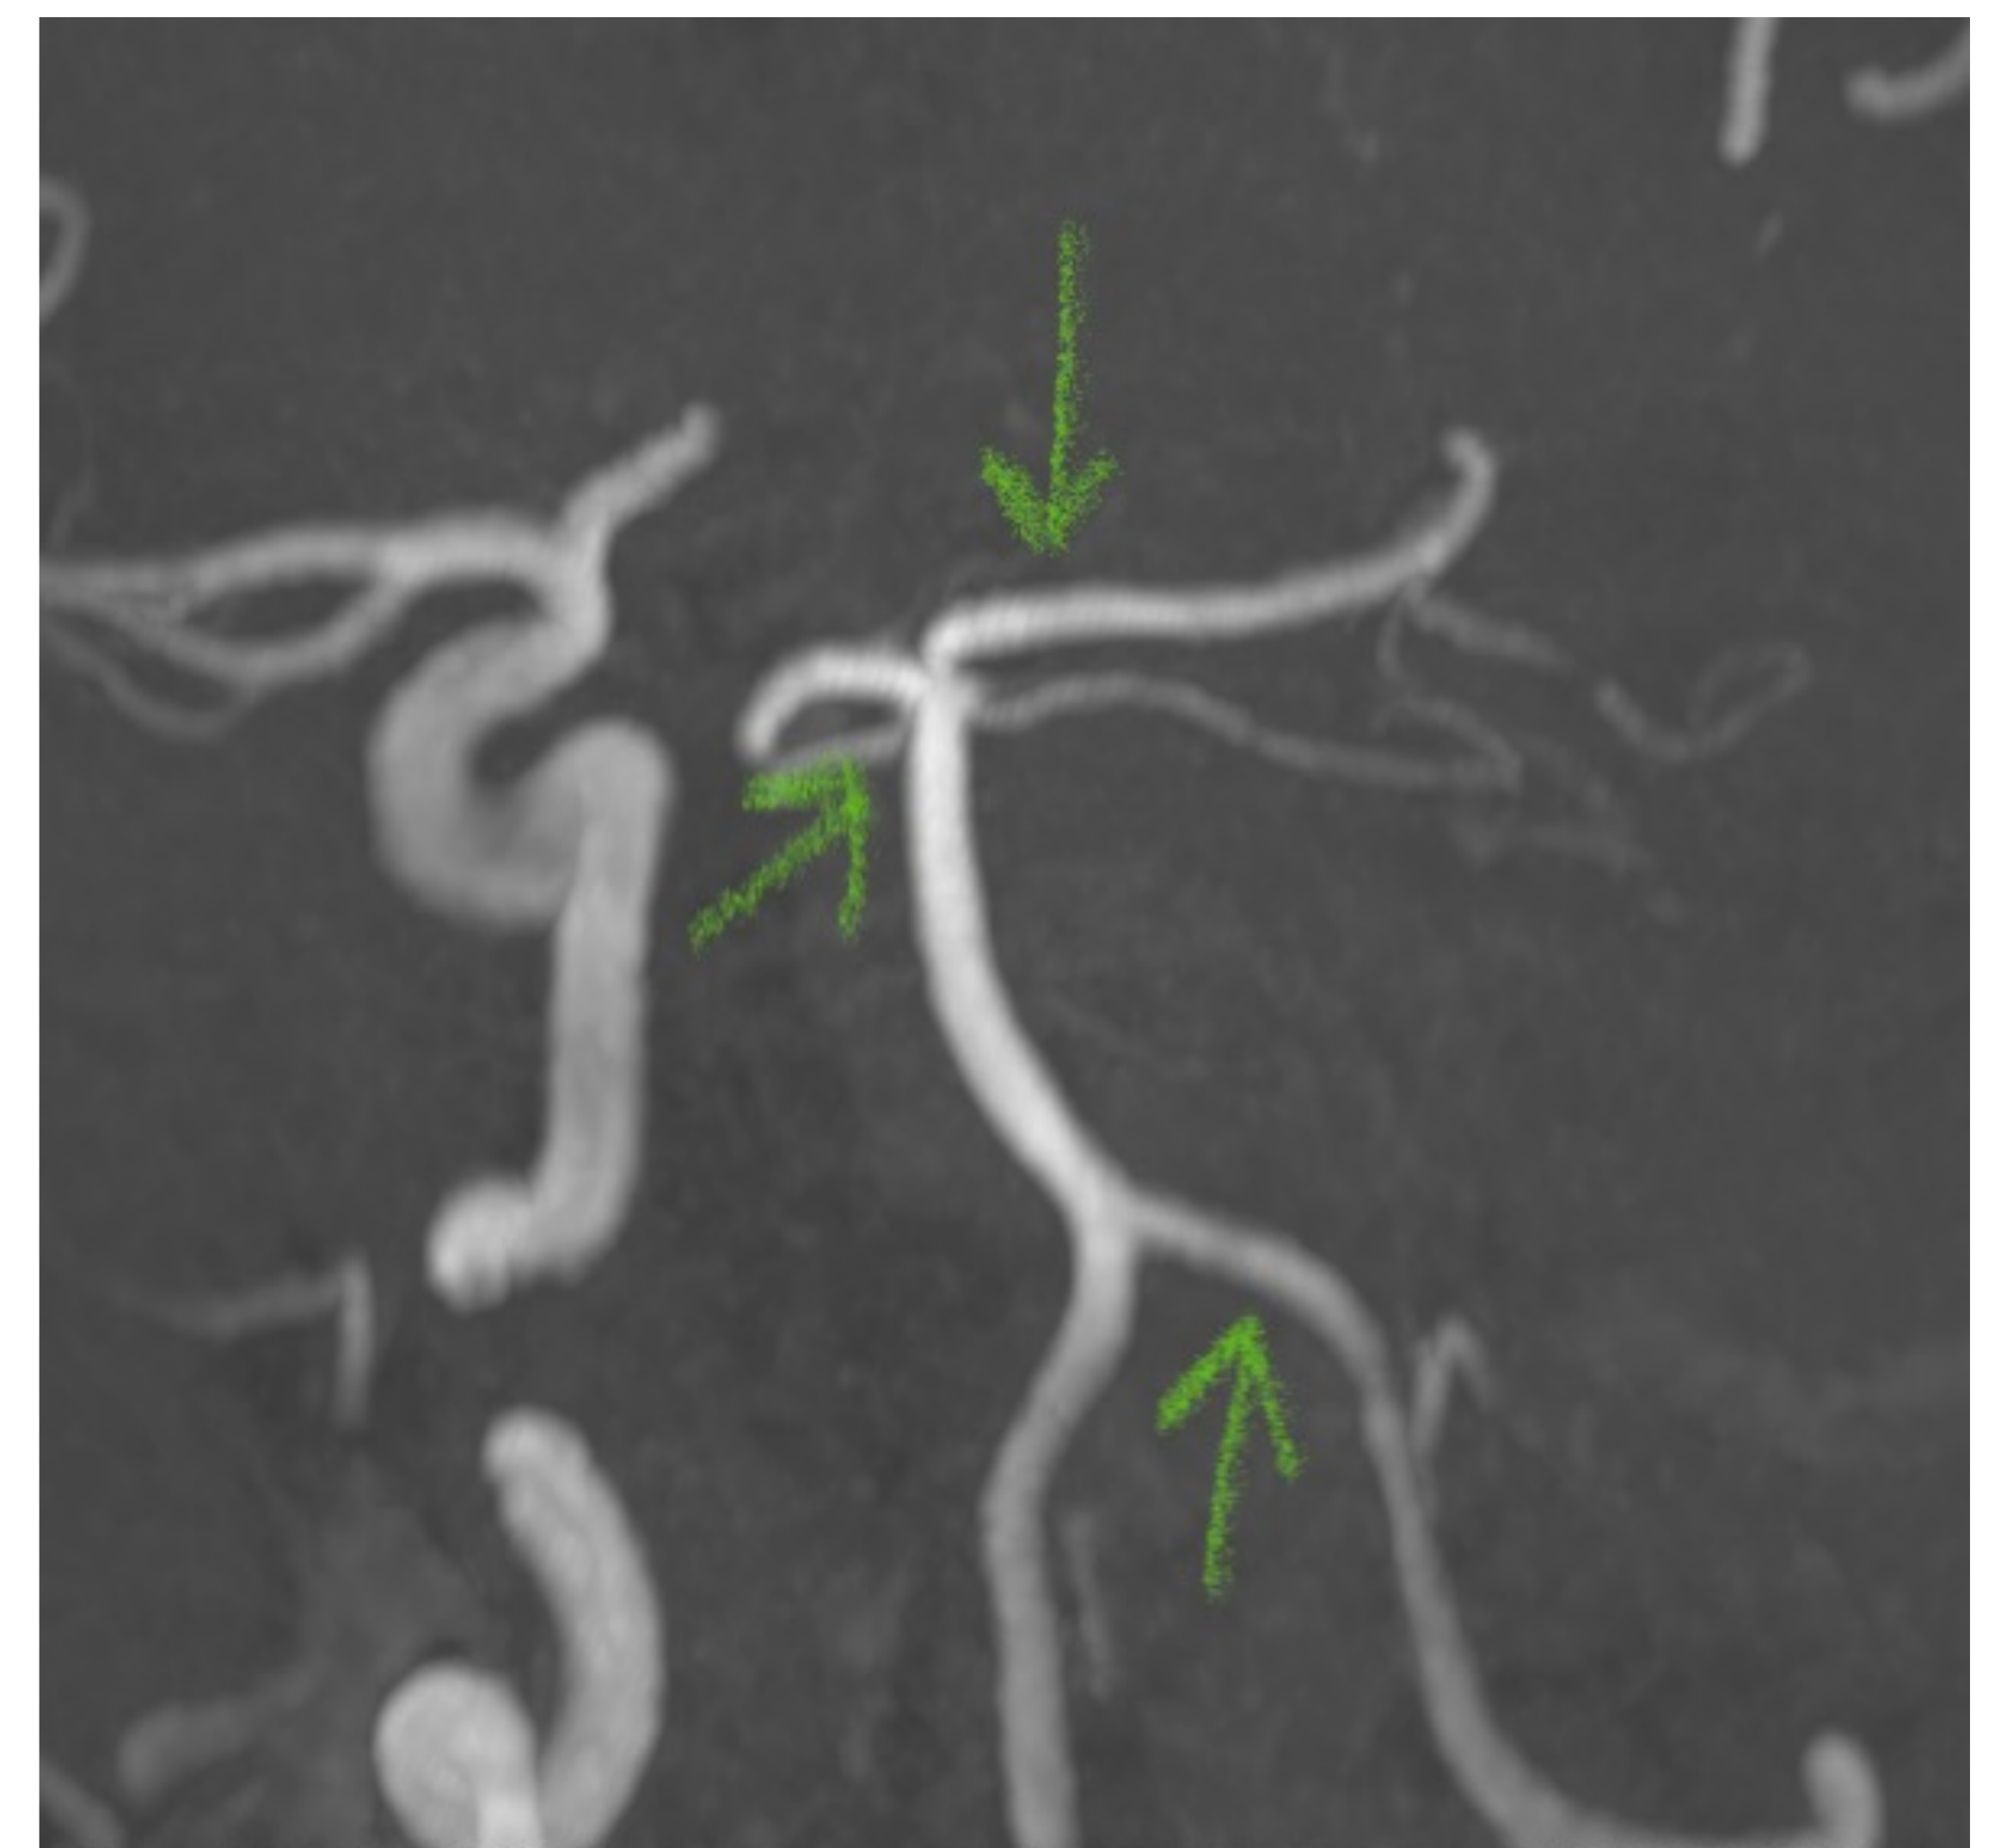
Follow-up MRI obtained 3 months after treatment, showing resolution of the lesions depicted in Figure 1.
